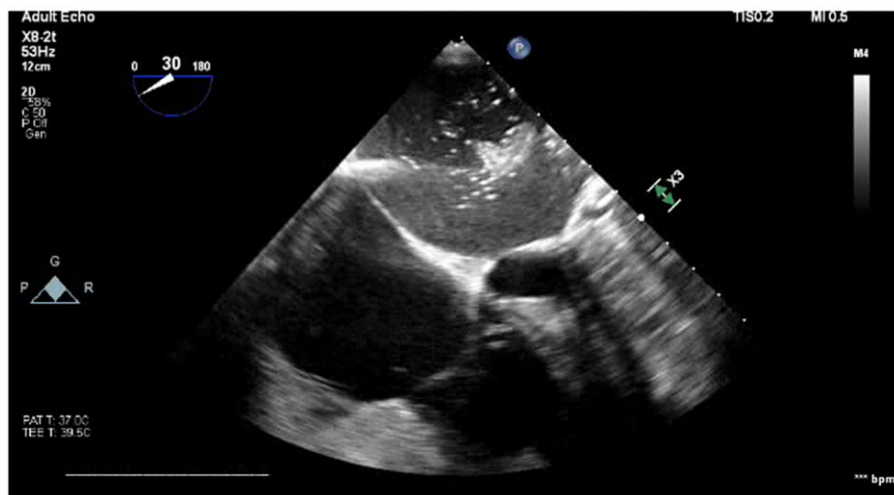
Transoesophageal echocardiography imaging showing dissolution of thrombus material.
